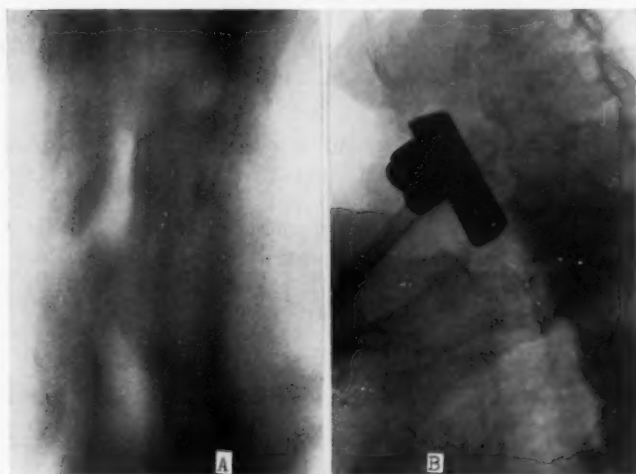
Planigraphy (A) shows the cervical trachea displaced slightly to the right and its lumen stenosed from the left side by external compression. X-ray film (B) demonstrates the retaining cannula in place. Note the wide lumen of the trachea.
